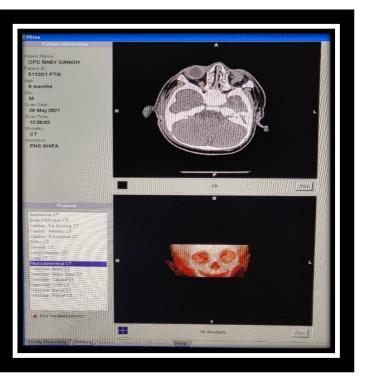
Vitrea software appreciating Musculoskeletal CT allowing both 2 & 3-D analysis
